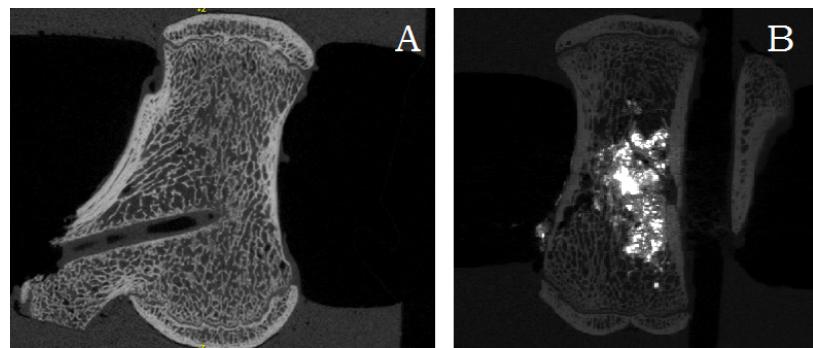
A: μ CT scan of an augmented vertebrae, with some visible PMMA residing in the needle channel. B: μ CT scan of an augmented vertebrae using PMMA mixed with barium sulphate.
